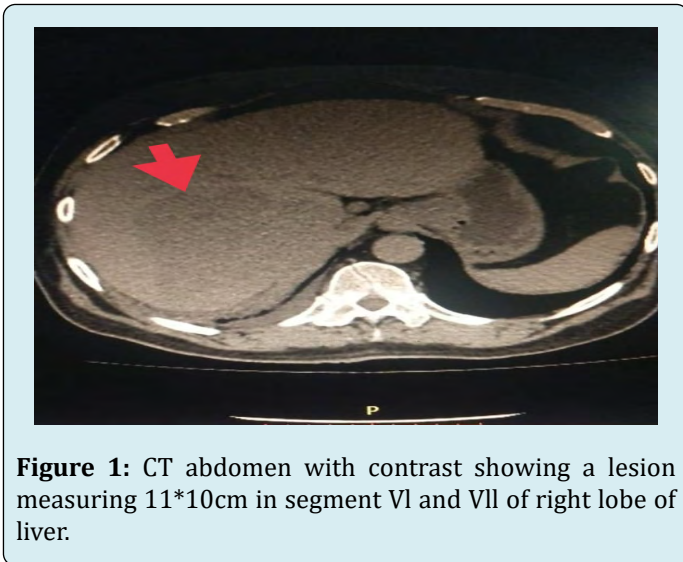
CT abdomen with contrast showing a lesion measuring 11*10cm in segment VI and VII of right lobe of liver.
